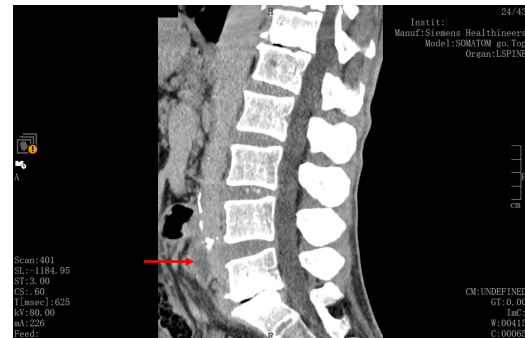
CT scan revealing a prevertebral abscess at L4-L5 level of 25x21x15 mm.
